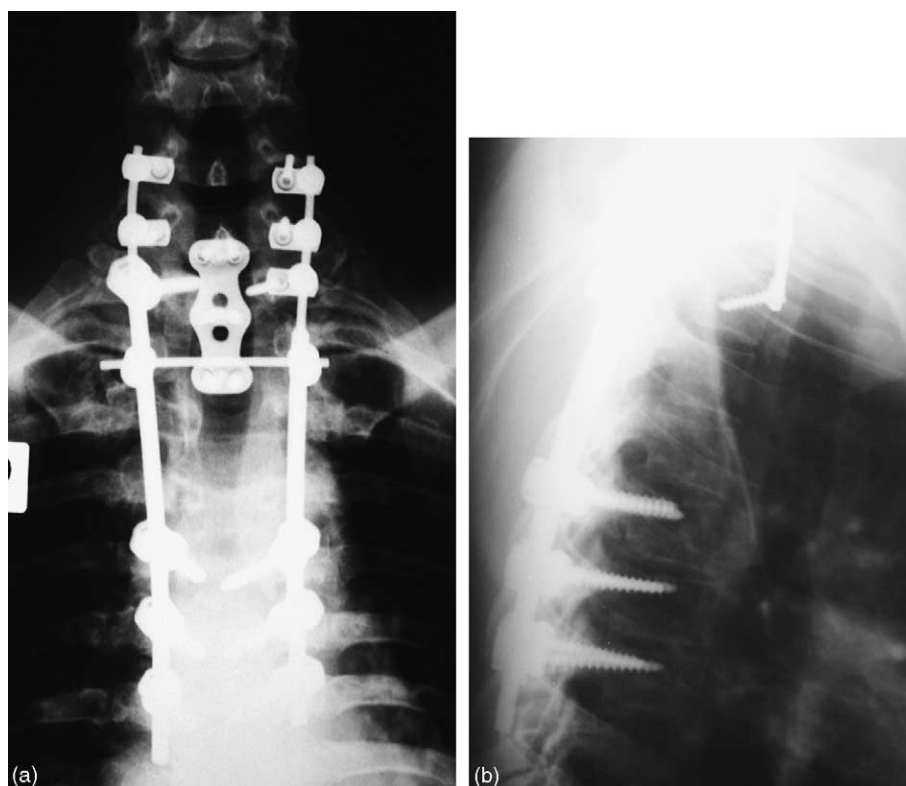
(a and b) Postoperative radiographs 1 year 5 months after surgery.
